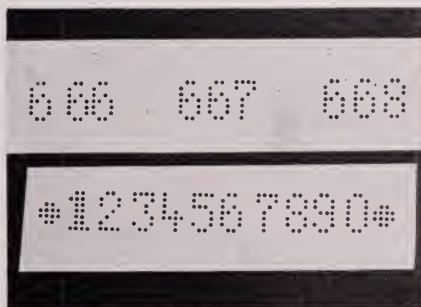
Print showing the appearance of the numbers on the x-ray plate.
